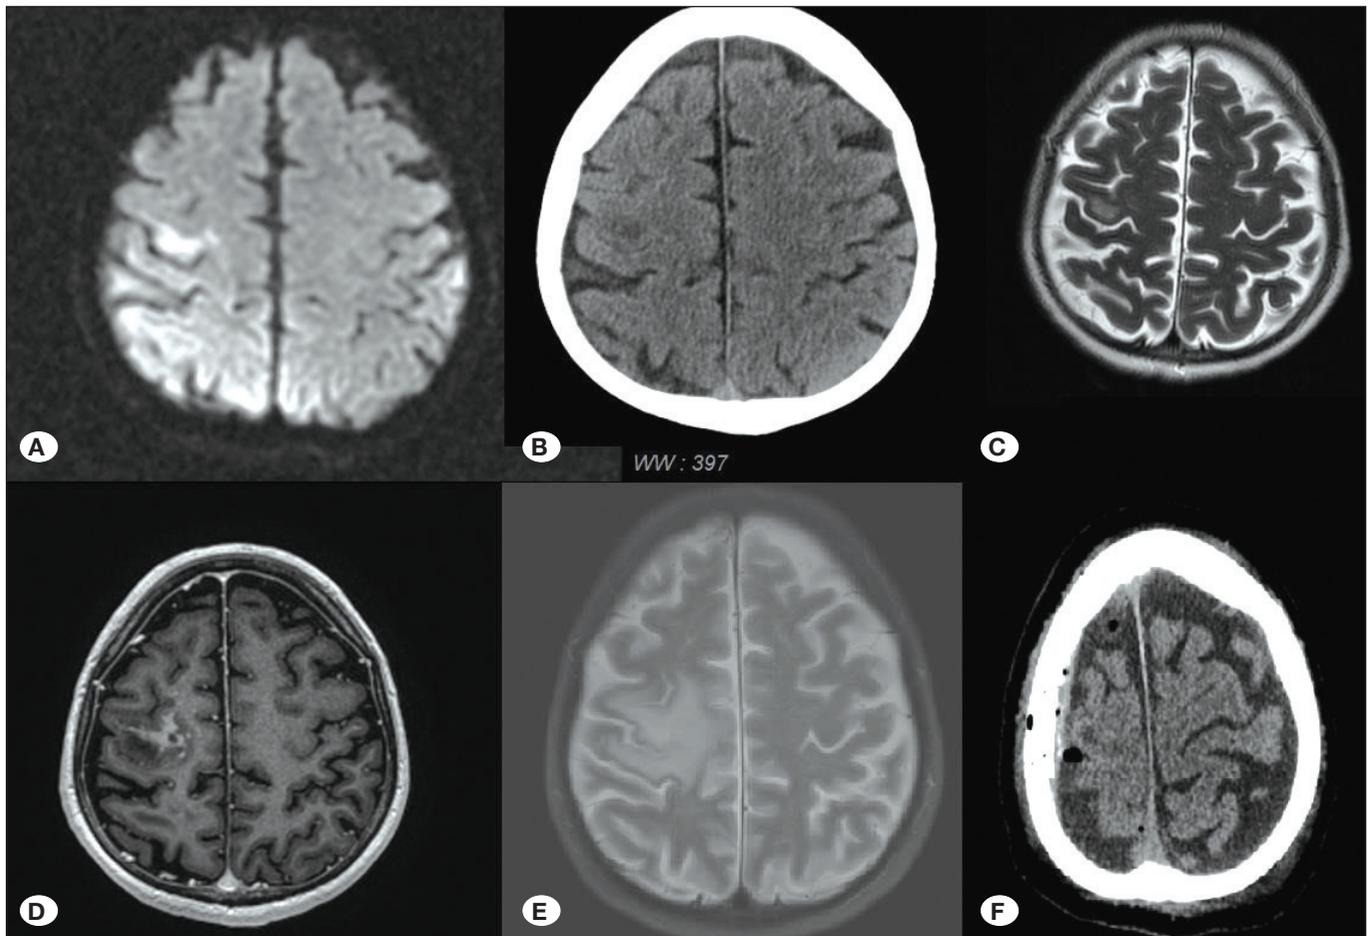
A) Axial section Diffusion MRI, B) axial section CCT, C) axial section T2W brain MRI D) 1st month axial section contrast enhanced T1W axial brain MRI, E) 1st month axial section T2 brain MRI, F) postop axial section CCT.
